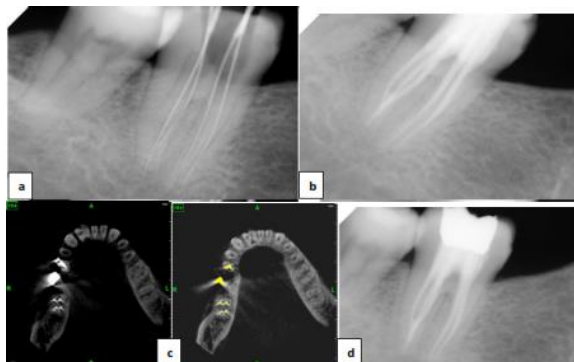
a) Radiograph with files in place for working length determination ; b) Control radiograph of filling quality immediately after root canal obturation; c) Post operative CBCT image showing five canals (2 in mesial and 3 in distal position); d) Control radiograph at 6 months.
